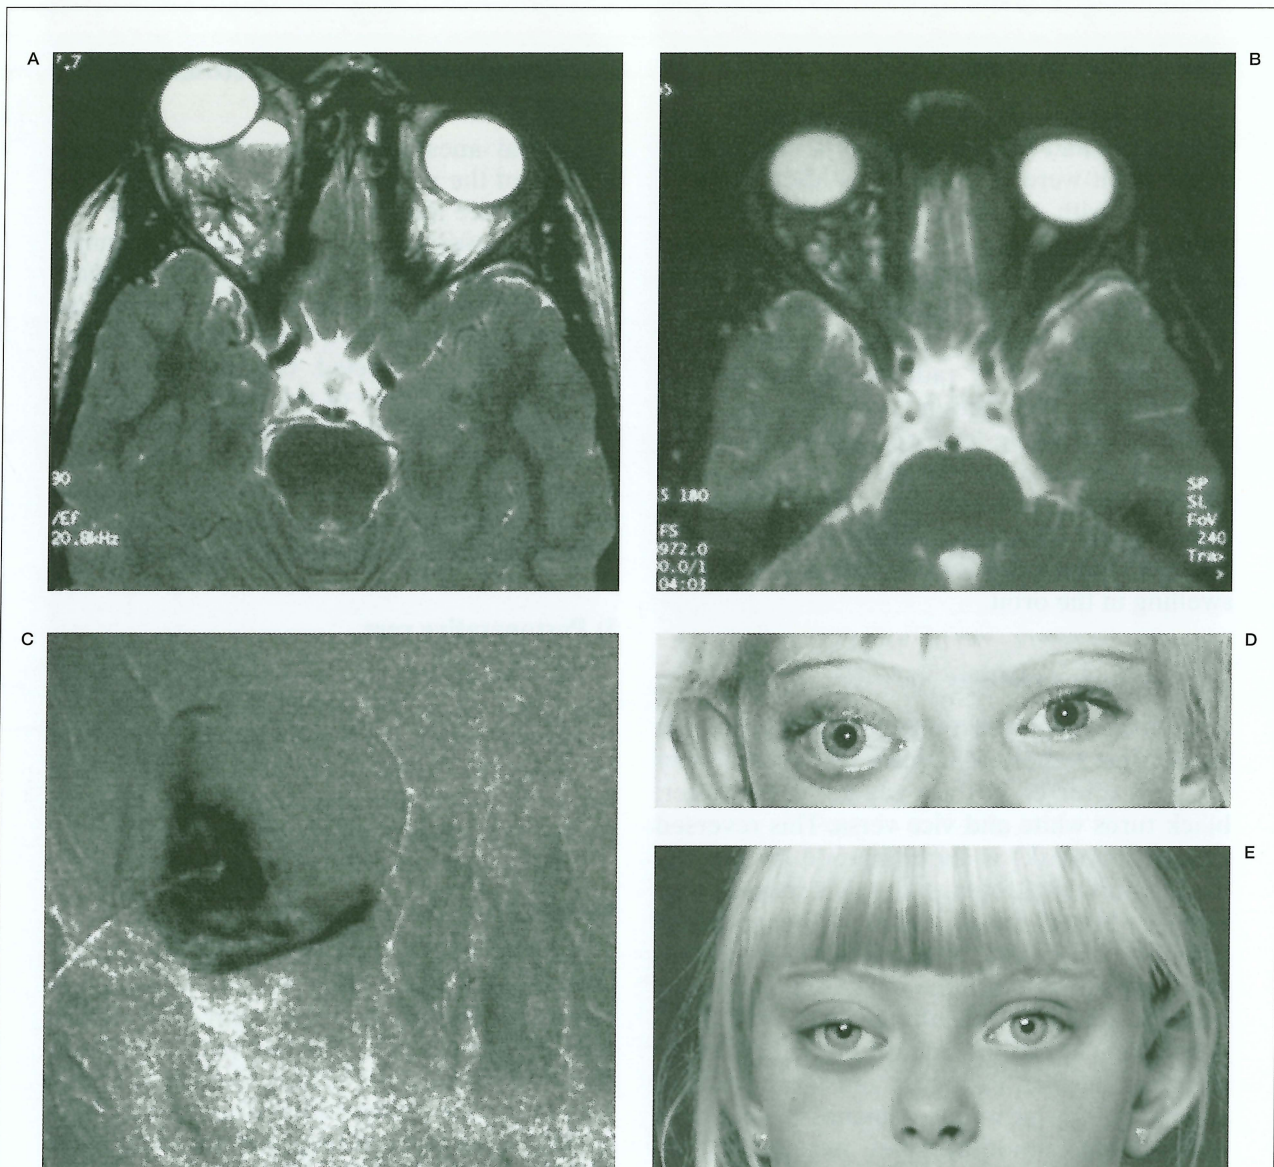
(Case 5) Moderate exophthalmos caused by masses in the right orbit, clearly visible on MRI before treatment (A). After one procedure the MRI showed small remnants four months later (B). Injection needle in position at Sotradecol treatment (C). Photograph of the eye before (D) and after treatment (E).
